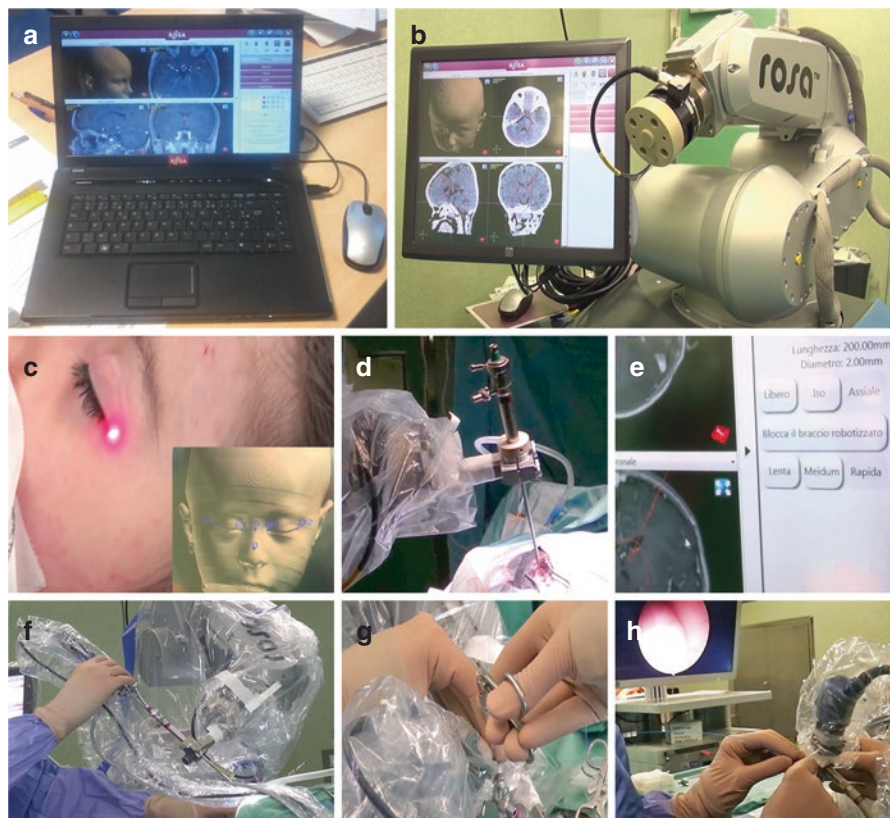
Main characteristics and setting steps of the ROSA system. (a) The preoperative trajectory is planned on a dedicated software using volumetric MRI and CT sequences; (b) The planning information is transferred to the robot system, which is composed of a platform, including a compact robotic arm and a touch screen, mounted on a mobile trolley; (c) Registration is performed by laser scanning system, starting from standard reference points on the face (inset); (d) Positioning of the endoscope held at the extremity of the robotic arm to the entry point, according to the planned trajectory; (e) Possible movement control modalities, including 3 modes (axial, isocentric, and free) and 3 speeds (slow, medium, or fast); (f) Intraoperative control of the endoscope; (g, h) The robot provides stable support to the endoscope, enabling the surgeon to manage the different instruments, such as pincers (g) or laser probe (h)
